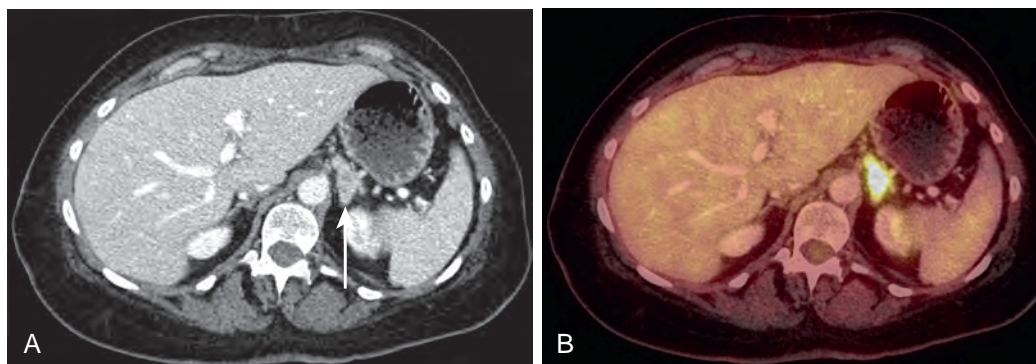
Adrenal metastasis from lung cancer. A. Contrast-enhanced CT demonstrates a 2.9-cm left adrenal nodule (arrow) that is incompletely characterized. B. PET/CT demonstrates increased FDG avidity in the nodule. Percutaneous biopsy was positive for adenocarcinoma from a lung primary.
